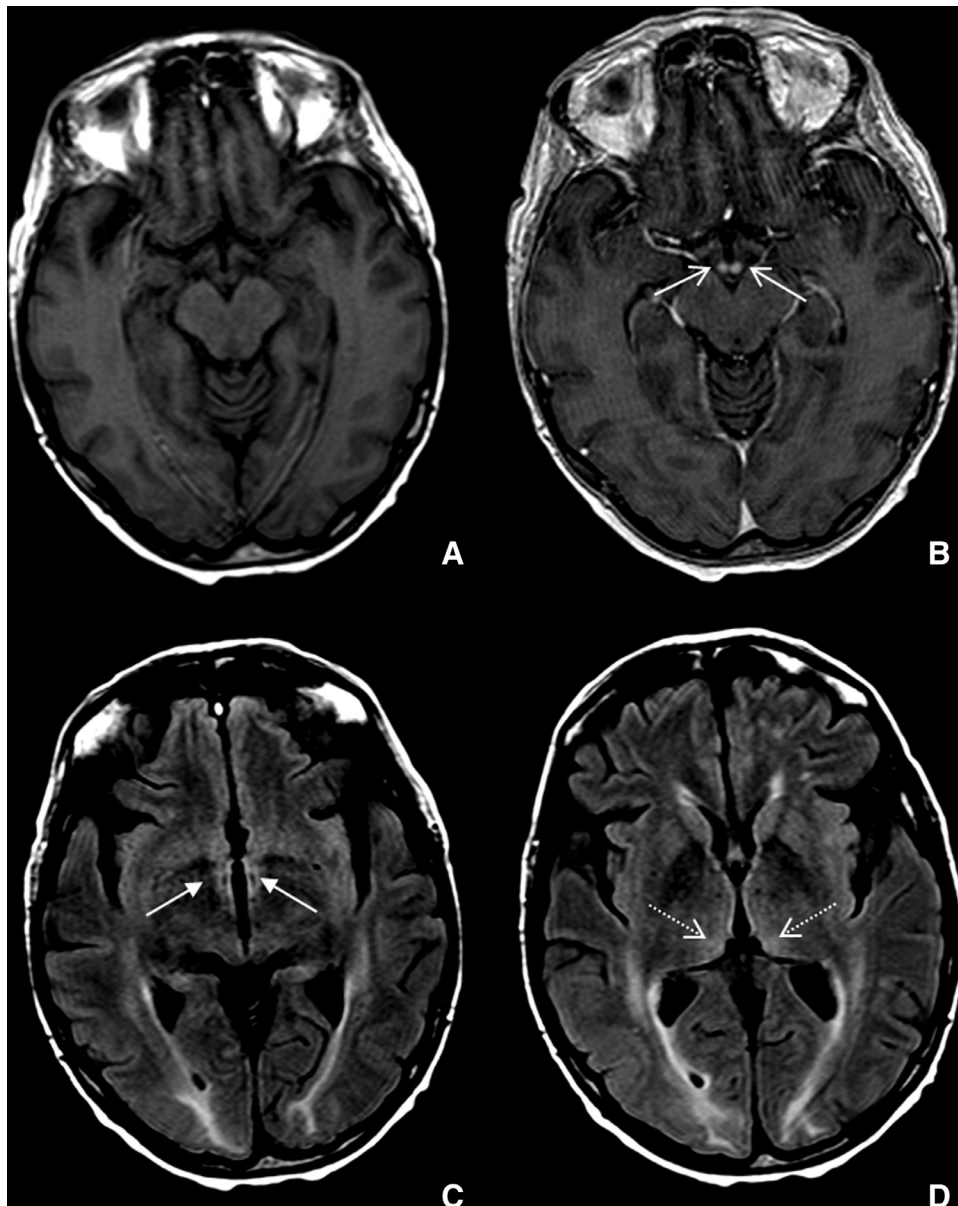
Wernicke Encephalopathy signs at MR examination. T1 Turbo Spin Eco (A) and T1 Fast Field Echo (B) after administration of gadolinium-based contrast agent, T2 FLAIR (C and D). To note the intense enhancing of mammillary bodies (open arrows in B) and the mild T2 hyperintensity to the gray matter around the third ventricle (close arrows in C) and in the thalamic pulvinar (dotted arrows in D).
